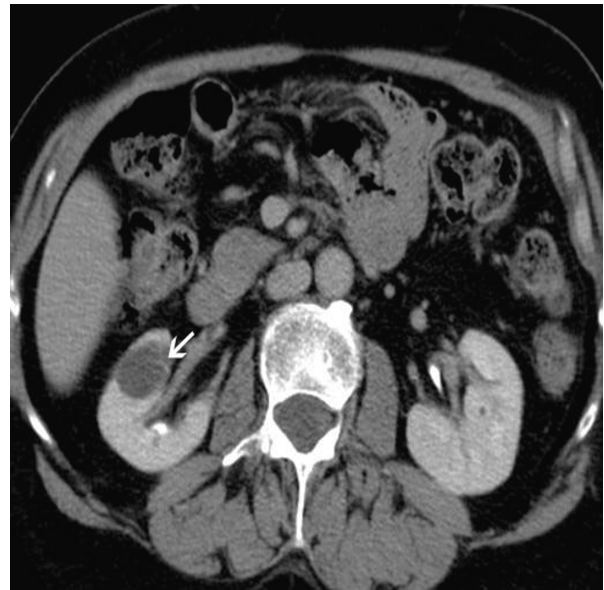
Minimally complicated cyst Bosniak category II. Axial contrast-enhanced CT shows a right renal cyst with a thin septation (arrow).
